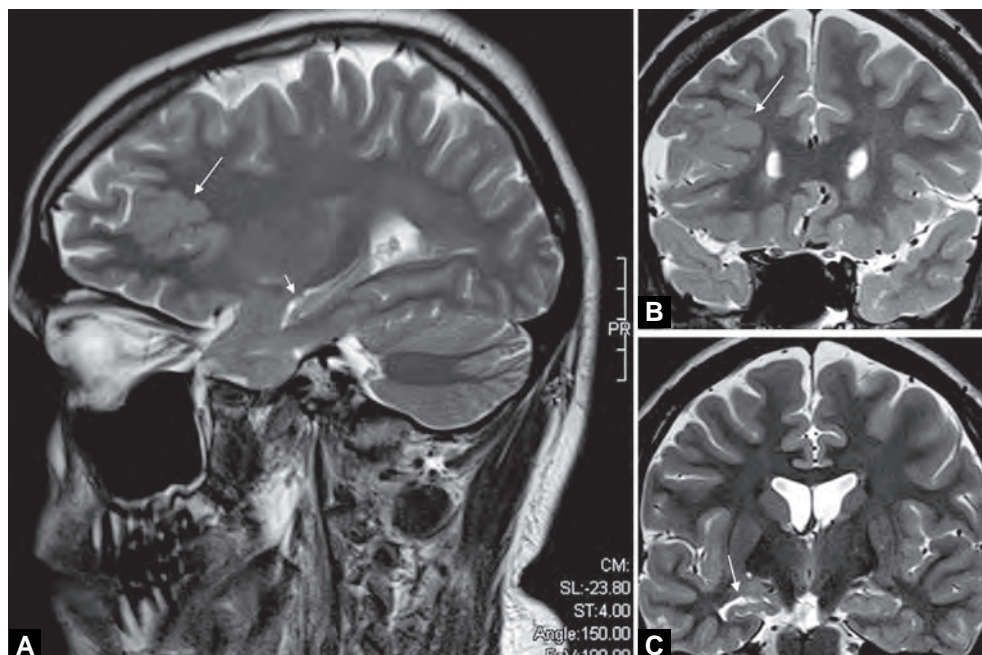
MRI and CT scan of the brain show lateral neocortical and mesial temporal lesions
